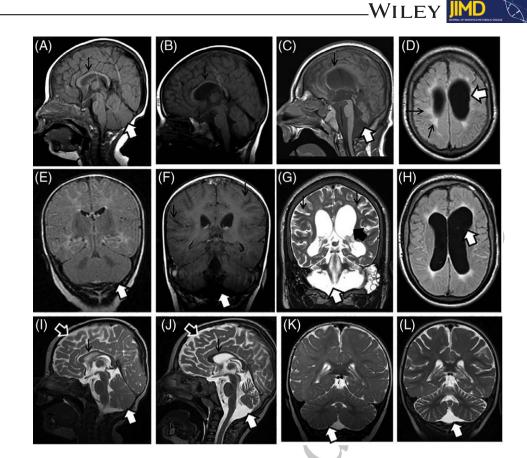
Typical MRI findings in ACO2 deficient patients. A to H are serial images of patient A2. A and E were taken at the age of 7 months, B and F at the age of 3 years C, D, G, and H at the age of 11 years and 8 months. A-C: T1-weighted image at similar sagital section showing initially (A) normal cerebellum (thick white arrow) and corpus callosum (thin black arrow) with progressive thinning of corpus callosum (B, thin black arrow) and severely developing cerebellar atrophy (C, thick white arrow). E-G: Similar coronal sections of T1-weighted (E, F) and T2-weighted (G) scans showing initially normal cerebellum (E, white thick arrow) and cortex with later gradually evolving vermian and hemispheral cerebellar atrophy as demonstrated by enlarged folia and decreased cerebellar volume (F and G, white arrow). In addition, progressive cortical atrophy is evident both peripherally (F and G, thin black arrows) and centrally as evidenced by enlarged lateral ventricles (G, thick black arrow). D and H are T1-weighted at axial section showing significantly enlarged ventricles "pseudo hydrocephalus" as a result of considerable central cortical atrophy (thick white arrow) associated with abnormal peri-ventricular white matter signal consistent with dismyelination (D, thin black arrow). I to L are serial images of patient E1. I and K were taken at the age of 7 months and J and L at the age of 2 years and 8 months. I and J are T2 weighted similar sagittal images showing already thin corpus callosum (I, thin black arrow) mild cortical atrophy (I, thick black arrow) and very mild cerebellar atrophy (I, thick white arrow) at the age of 7 months with later almost disappearance of corpus callosum with only remnants of its posterior part (J, thin black arrow) and progressive cerebellar atrophy as evidenced by its volume loss (J, thick white arrow). K and L are T2 weighted similar coronal scans showing mainly progressive cerebellar atrophy (K and L, thick white arrows) with less prominent cortical atrophy
